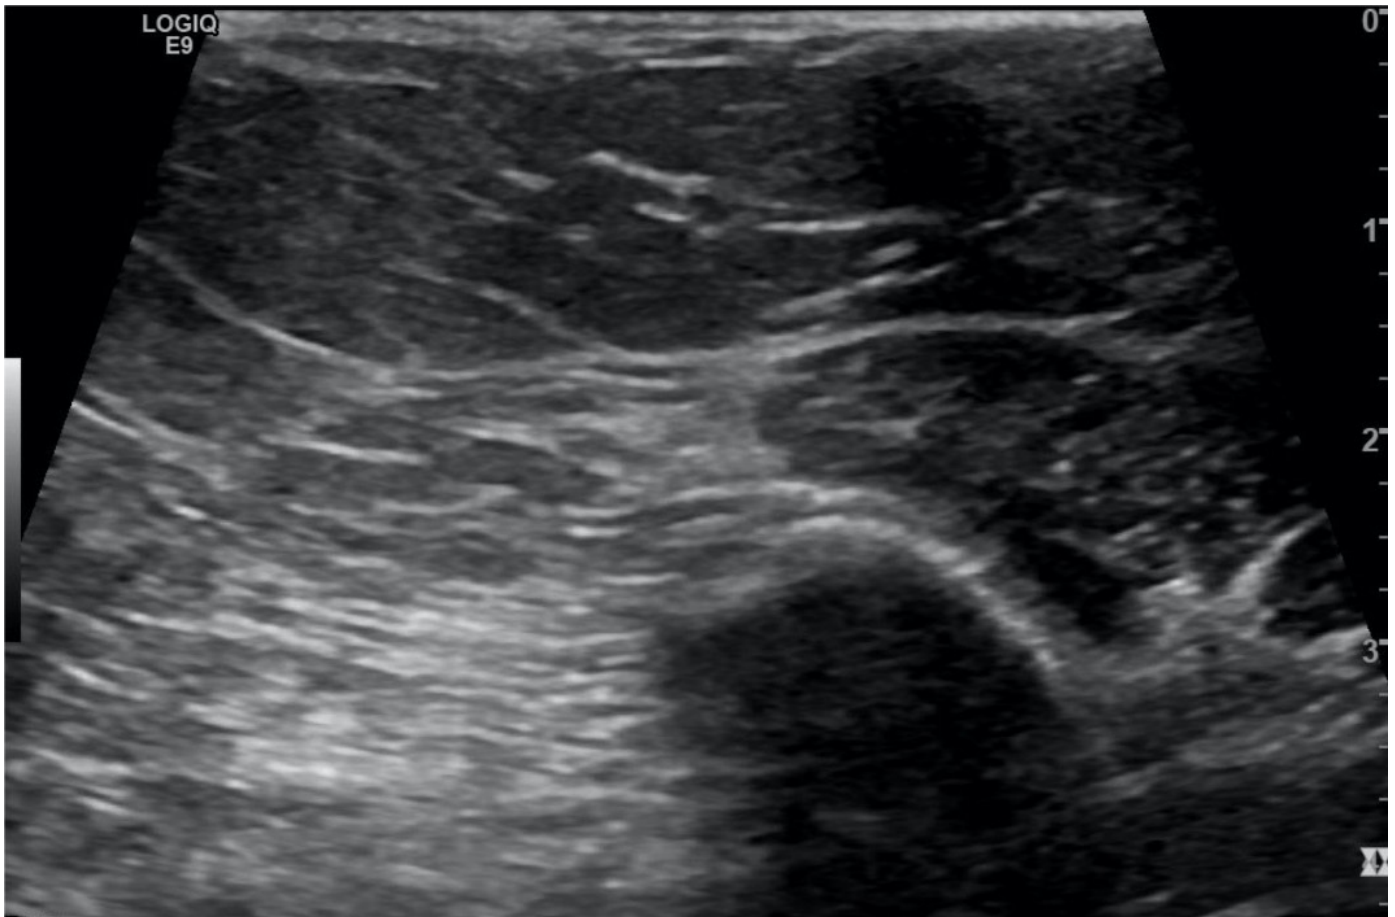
Follow up ultrasound images after 1 month showing resolution of axillary lymphadenopathy.
